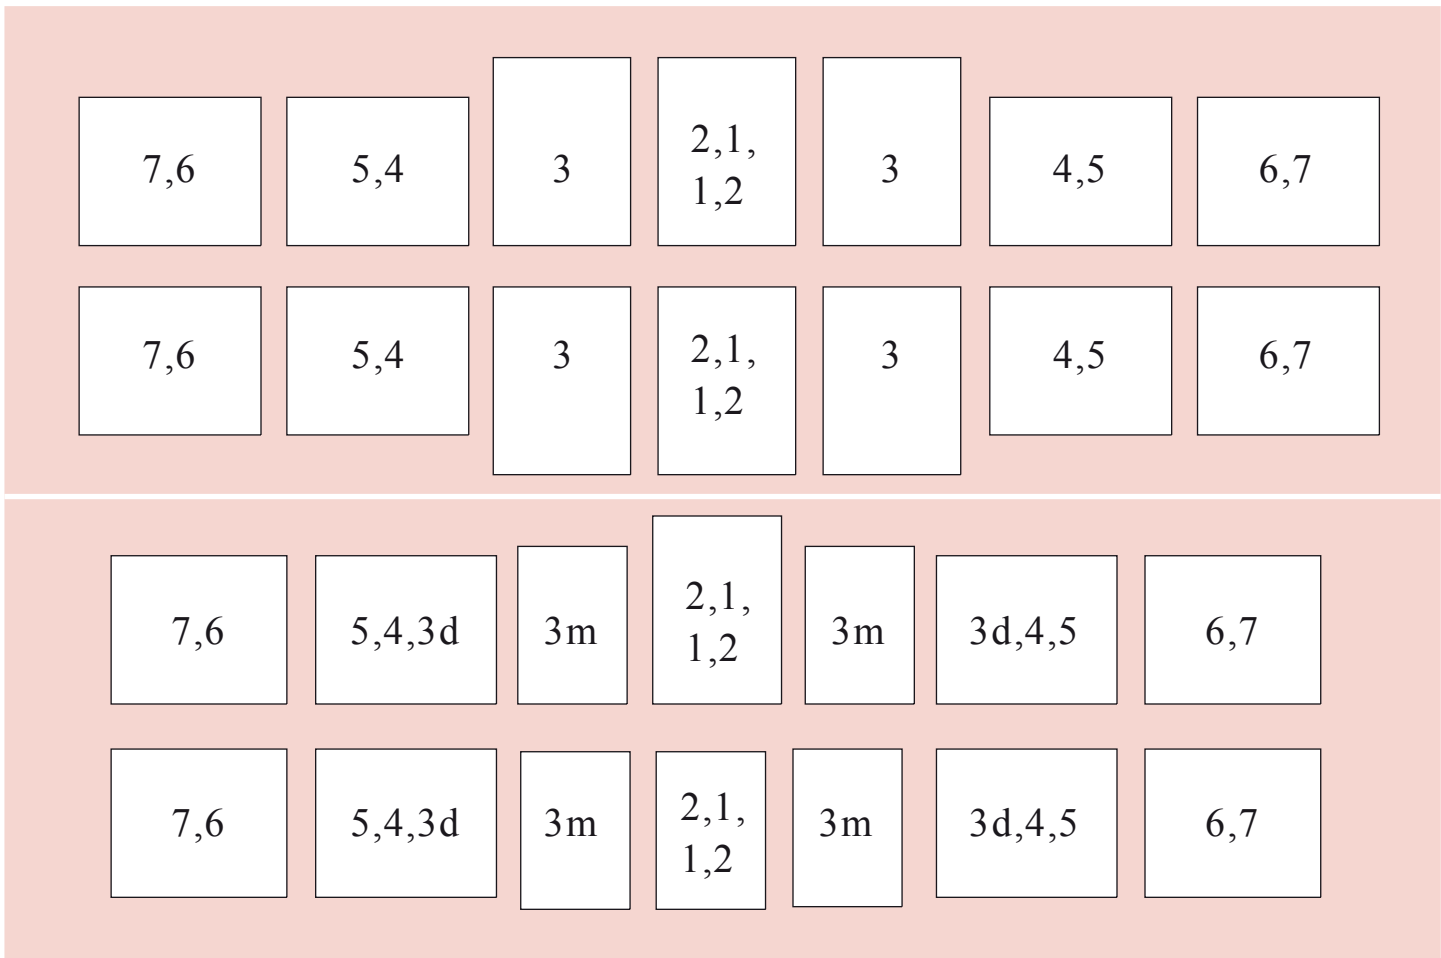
Full-mouth series of 14 radiographs. The upper panel shows the usual full-mouth series for adults, and the lower panel shows that used for evaluation of the periodontal status. The numbers reflect the tooth numbers. M: mesial; d: distal. (From: Pasler FA, Visser H. Zahnmedizinische Radiologie. 2nd ed. Stuttgart: Thieme; 2000. Farbatlant der Zahnmedizin; Band 5.)
